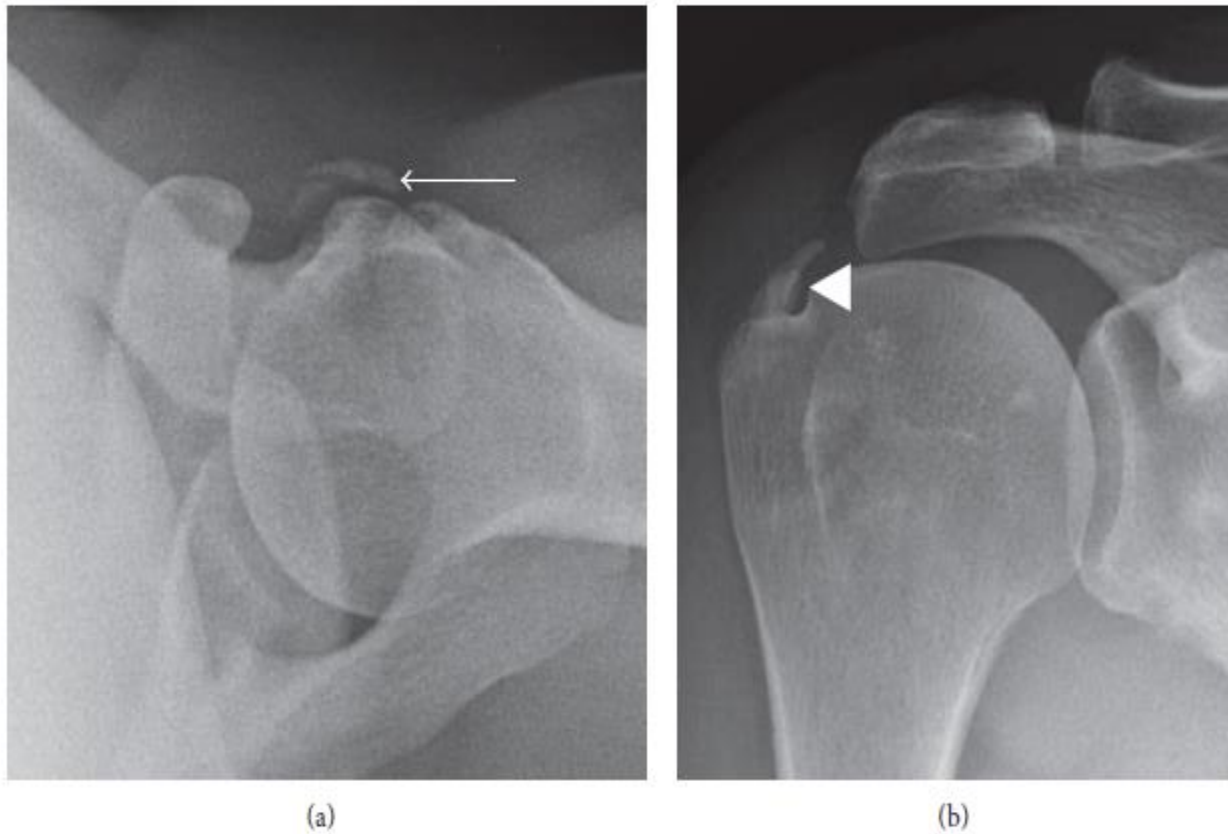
Radiographic appearance of calcific tendinopathy. (a) Fluffy, ill-defined, and inhomogeneous appearance of calcifications (arrow) typical seen in acute symptomatic patients. (b) Discrete, homogeneous, and well-defined appearance of calcifications (arrowhead) typically seen in asymptomatic or chronic symptomatic patients.
